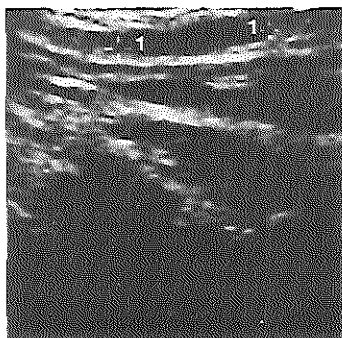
The ultrasound presentation of the same fistulous tract as shown in fig. 4a. Longitudinal view of the cystic dilatation of the most caudal part of the fistula.
